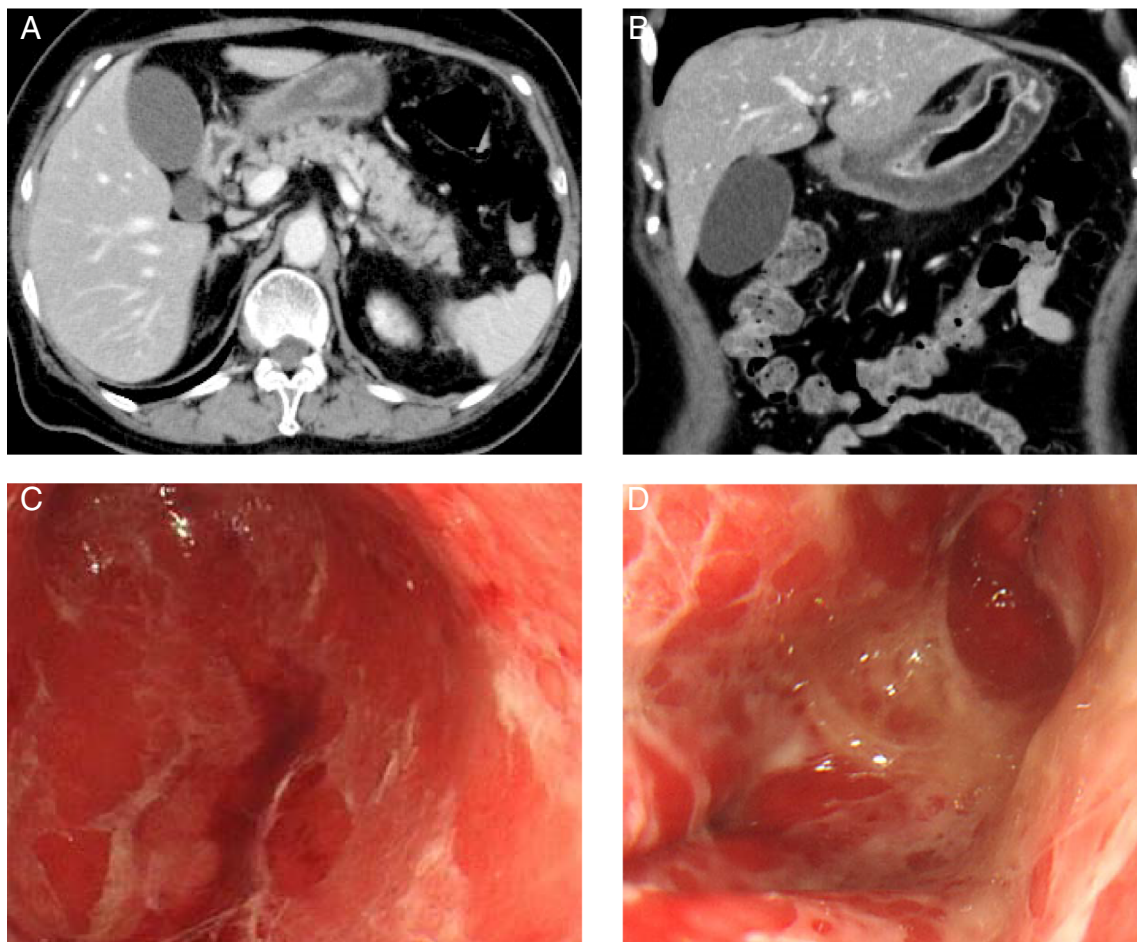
Computed tomography (CT) image showing gastric wall thickening (A, B) and endoscopic findings showing extensive gastric mucosa erythematous with a white coating (C: pylorus, D: antrum).
